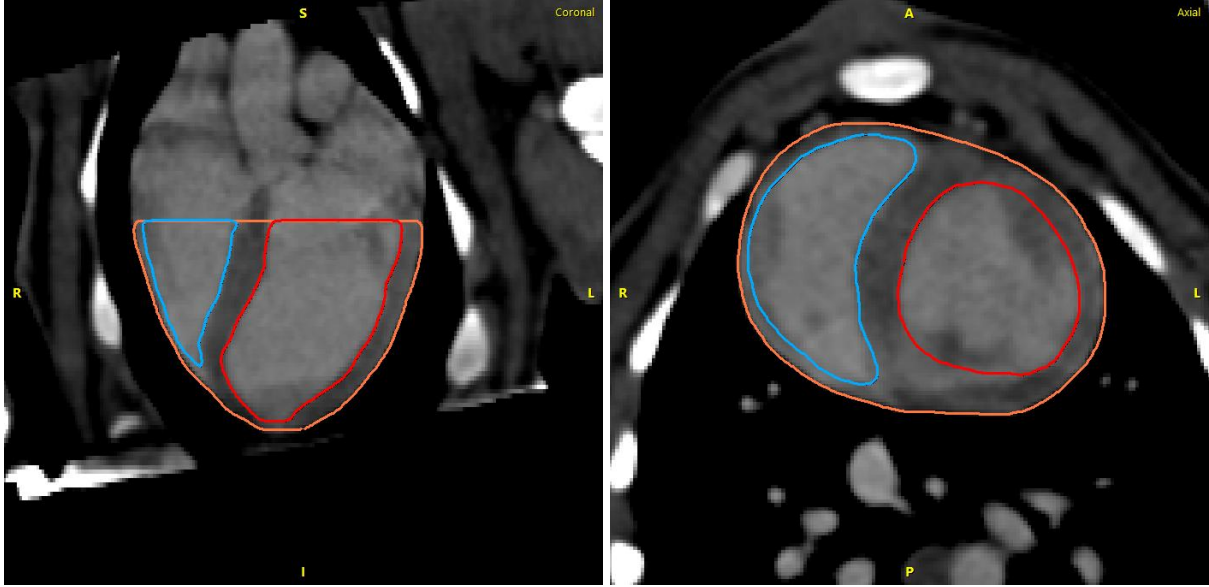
Exemplary CT image of the heart at the 80% diastolic state. On the left side is the coronal view, and on the right side is the axial view. The left ventricle is marked in red, the right ventricle in blue, and the outer layer of the myocardium in orange.
